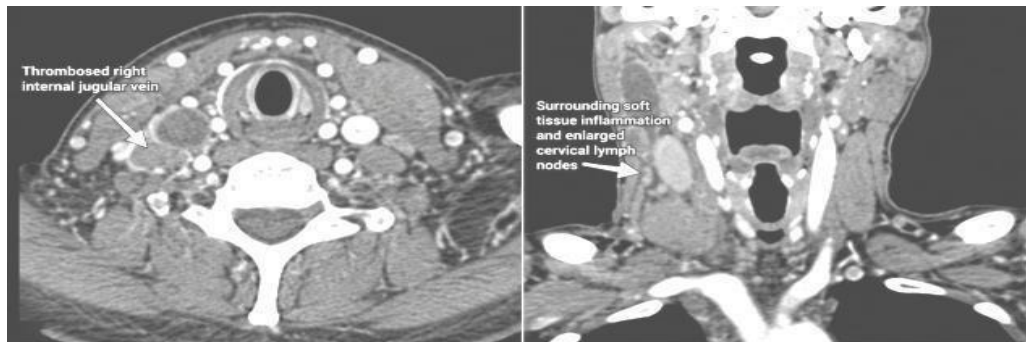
Contrast-enhanced CT neck showing thrombosis of the right internal jugular vein with surrounding soft tissue inflammation.
